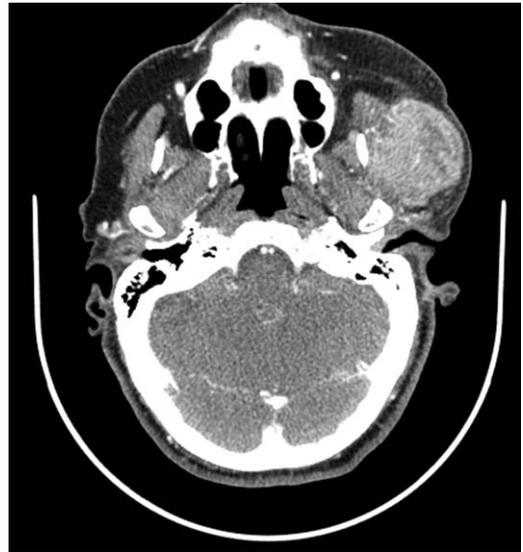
CT scan obtained at diagnosis showing an enhancing left parotid mass.
